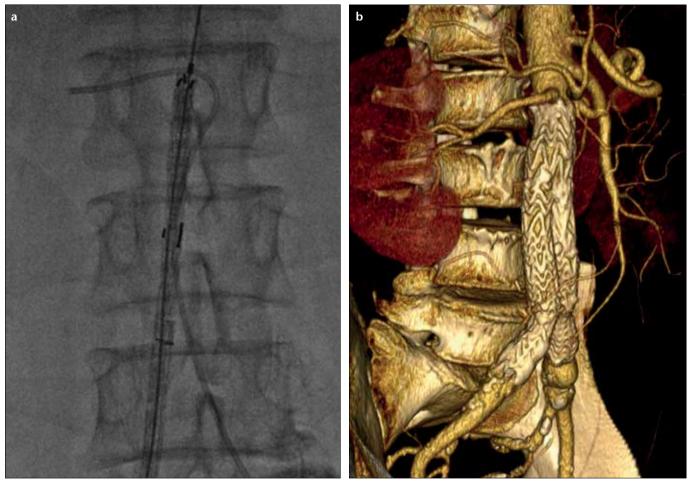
a, b. A fluoroscopic image (a) showing cannulation of the inferiorly positioned right renal artery with a Simmons-1 catheter. The main body of the Gore Excluder stent graft is advanced to the level of the catheter's fulcrum, which contacts the inferior border of the renal artery at the level of its orifice. At this point, the tip of the main body and the Simmons catheter are in contact with each other (a). Volume rendered CT image obtained on the 3rd day after the procedure (b) shows that the proximal tip of the stent graft is at the same level as the inferior border of the right renal artery.
